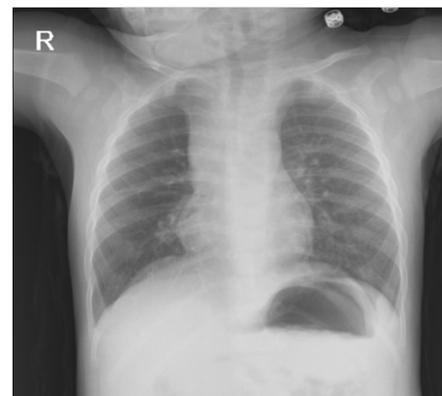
Chest X-ray of the case.
